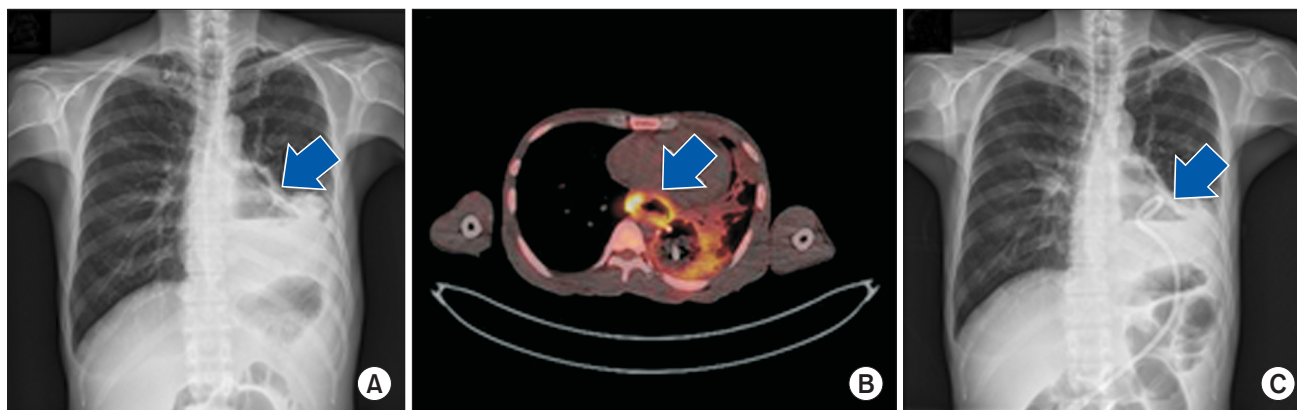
Chest X-ray and PET/CT findings of a patient with advanced esophageal cancer who had an ERF. (A) The arrow indicates a lung abscess in the left lower lobe. (B) On PET/CT, a fistula is seen to have developed by rupture of a huge tumor of esophageal cancer, in which PET showed the highest metabolism anywhere in the esophagus. (C) For infection control, percutaneous catheter drainage was performed before surgery. PET, positron emission tomography; CT, computed tomography; ERF, esophageal-respiratory fistulas.
